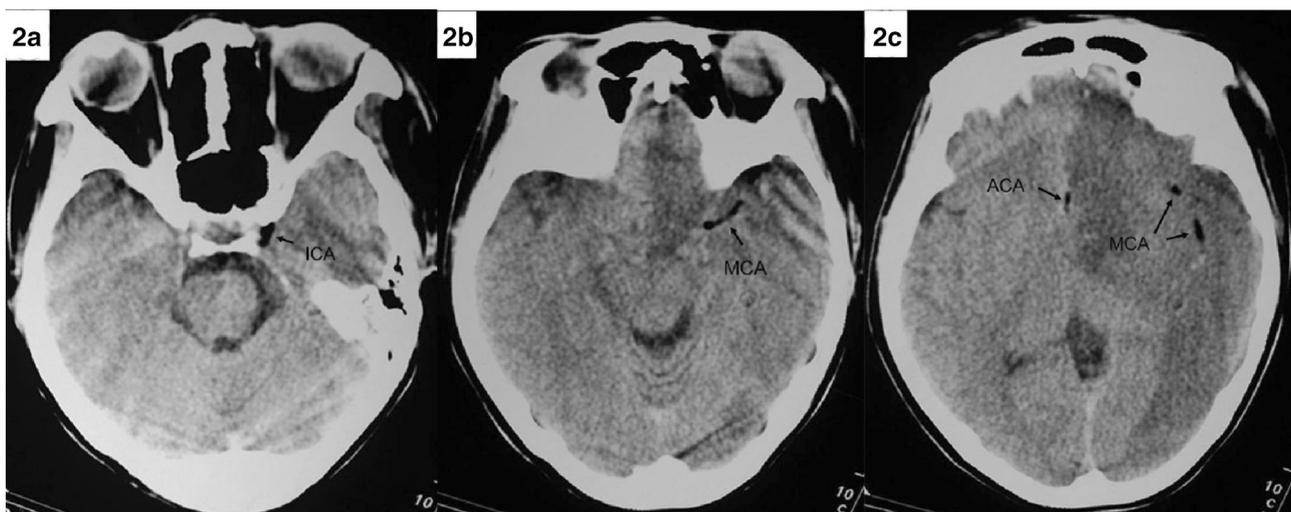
a–c Brain computed tomography in patient showing acute infarction in the left frontal–temporal–parietal lobes and signals suggesting fat or air in the internal carotid artery (ICA), anterior cerebral artery (ACA) and middle cerebral artery (MCA)
